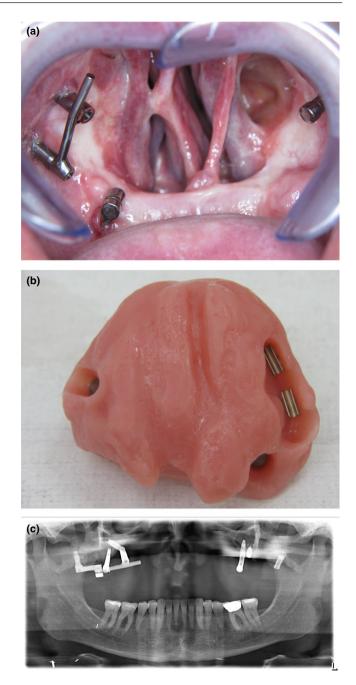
A patient presented with a Brown class IId defect (Brown & Shaw, 2010) after avascular necrosis after Le Fort I osteotomy. (a) Bar construction was made on the dental implants to support the obturator, where the space was too large between two implants, magnet abutments were used as alternative retention method. (b) Retentive parts in the obturator prosthesis. (c) Panoramic radiography showed the position of dental implants in remaining bony parts of the midface or skull base
